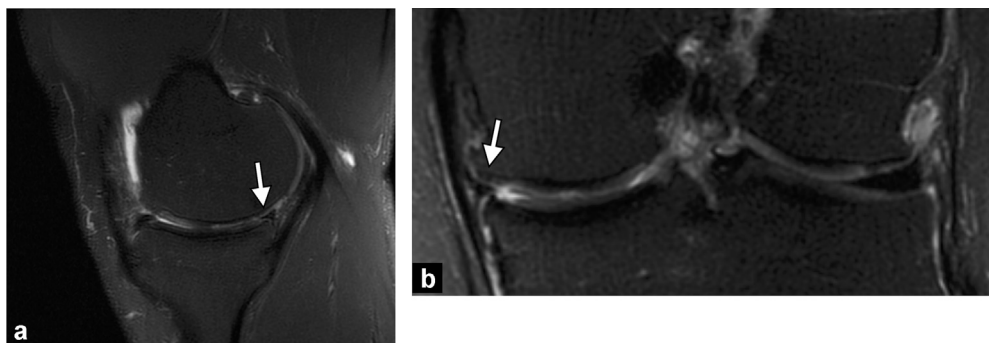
Normal appearance after partial meniscectomy. Loss of substance and amputation of posterior horn and substance of the medial meniscus (arrow). Sagittal (a) and coronal (b) fat-suppressed PD-weighted MR images.
